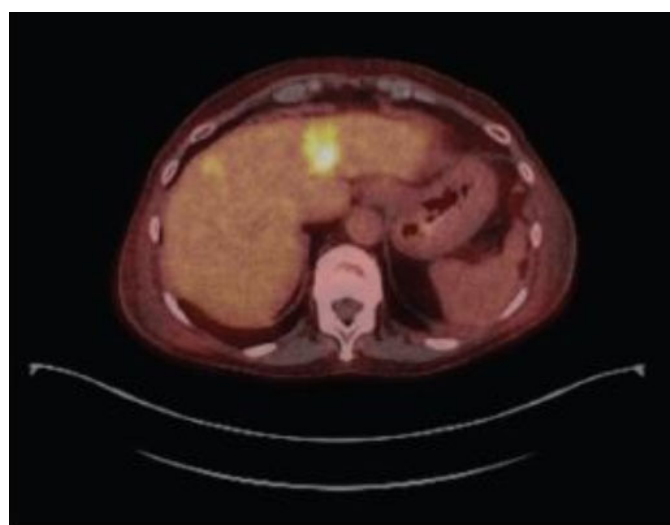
PET imaging showing FDG uptake in the two liver lesions identified as metastatic colon cancer.
